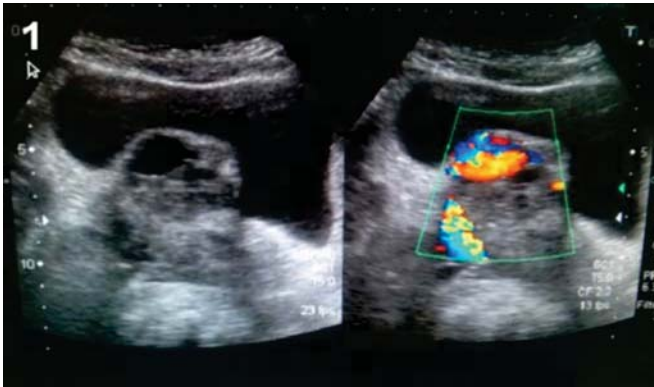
Pelvic USG showing empty cystic spaces with enhanced blood flow on color doppler.
